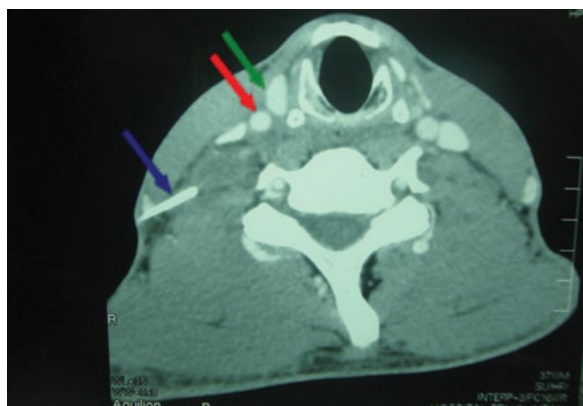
Computed tomography scan showing the fish bone (blue arrow) protruding out of the scalene muscle below the skin (green arrow: internal jugular vein; red arrow: common carotid artery)
